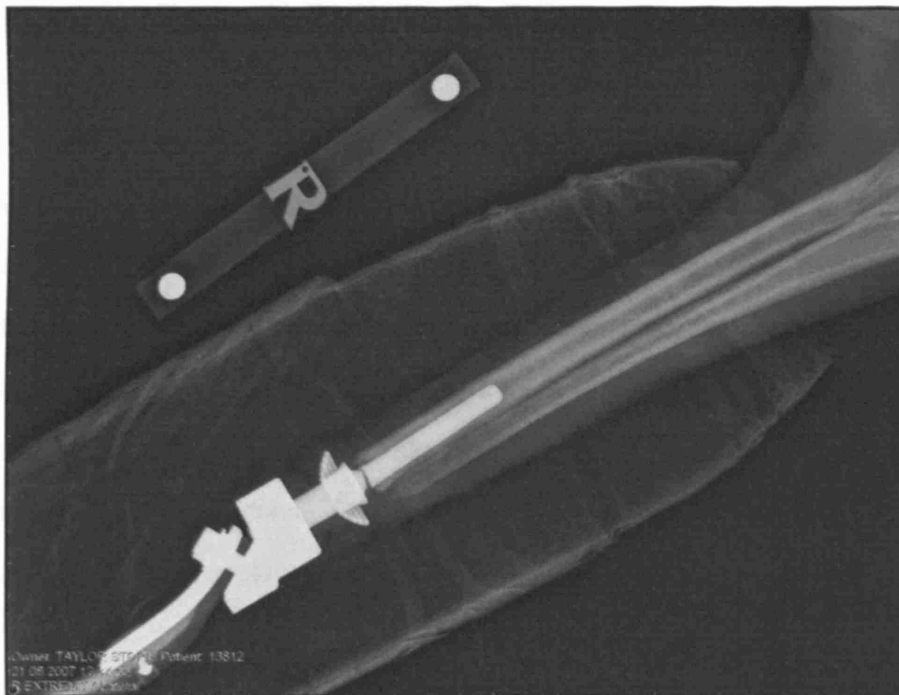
Radiograph of Storm's fractured implant. Courtesy of Professor Blunn, University College London.
